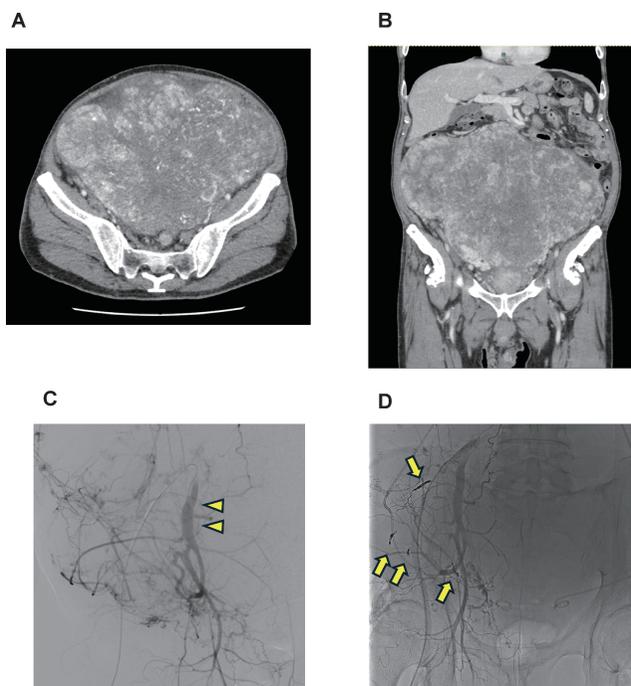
A case of intrapelvic undifferentiated pleomorphic sarcoma. Axial (A) and coronal (B) computed tomography images indicate a large tumor originating from the pelvic floor. Several branches from the right internal iliac artery (arrowheads) fed the tumor, and these are embolized with multiple coils (arrows) one day before surgery (C, before embolization; D, after embolization).
